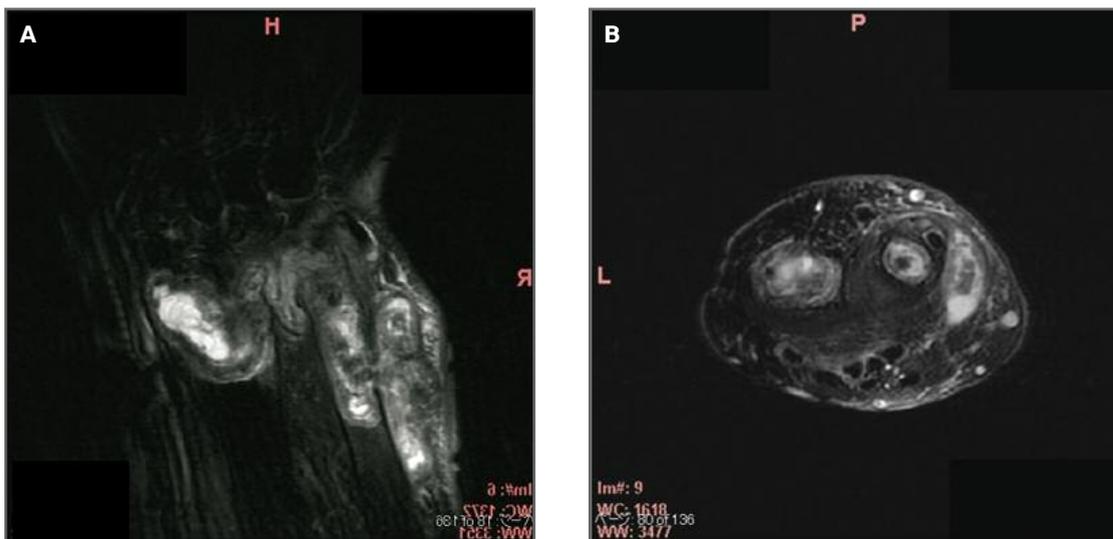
Preoperative MRI of the right wrist. A) Coronal image with fat-suppression (chemical shift selective method, CHESSE). The mass with increased signal intensity was found in the distal radius and ulna, distal radio-ulnar joint, and under the subcutaneous tissue. The ulnar mass continued from the ulna to the fistula. B) Sagittal image with fat-suppression (CHESSE). The mass with high signal intensity was found in the radius, ulna and ulnar subcutaneous tissue of the distal forearm, and the signal intensity of three lesions were almost same
